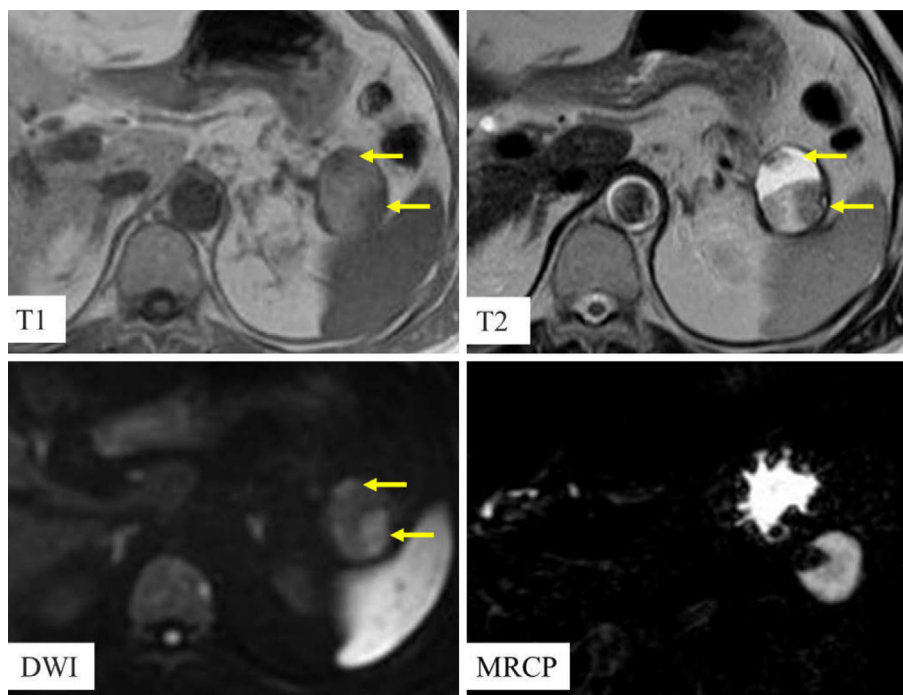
MRI scan acquired before surgery. Nodules showing a low intensity on both T1WI and T2WI and a high intensity on DWI (arrow). DWI: diffusion weighted imaging, MRCP: magnetic resonance cholangiopancreatography
